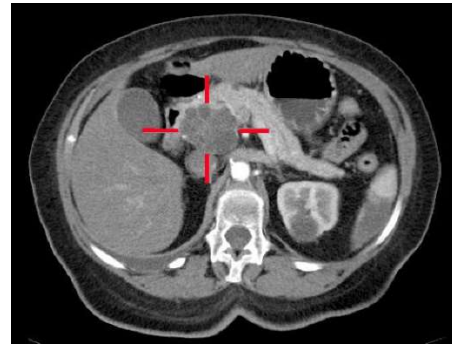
Abdominal CT showing an adenocarcinoma of the head of the pancreas. Source:
